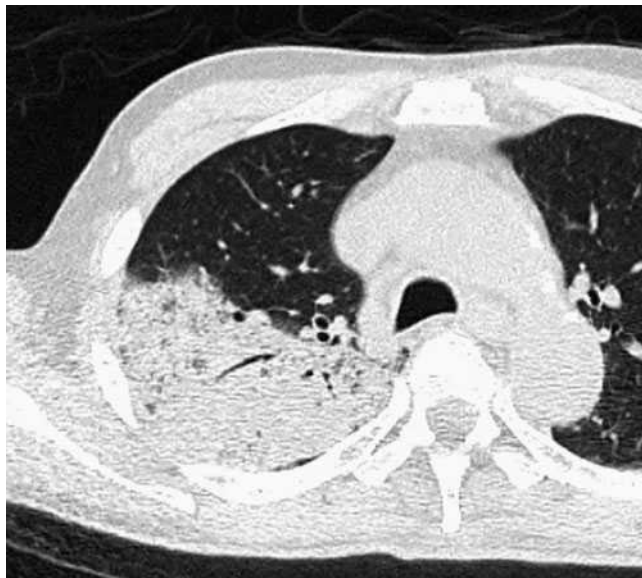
Acute pneumonia caused by *Streptococcus pneumoniae* alone in a 65-year-old male, 3 days after the onset of fever, cough and dyspnoea. Transverse CT image at the level of the right upper lobe shows consolidation.
